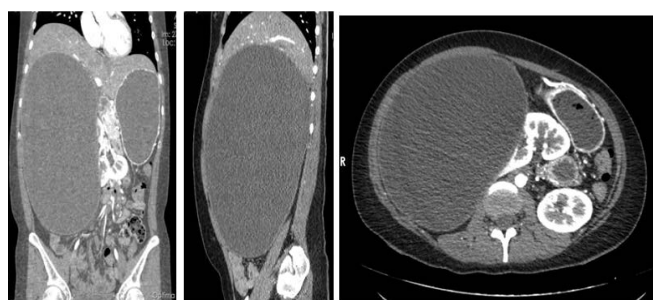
Contrast-enhanced abdominal CT in coronal, sagittal, and axial planes. A large hypodense cystic lesion with well-defined contours and thin walls is identified in the upper pole of the right kidney.
